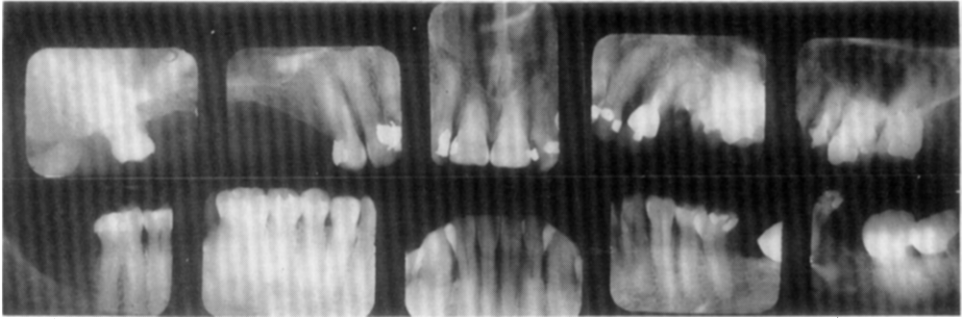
D and E. The oral rehabilitation of a 45-year-old woman who has diabetes. Systemic disease plays an important role in the failure of some oral rehabilitations: *D*, radiographs made two years postinsertion (in spite of continuous specialized periodontal treatment and a team of medical specialists treating her for diabetes, the periodontal breakdown continued at an alarming rate); *E*, radiographs made in 1969 reveal the severe periodontal pathosis.
